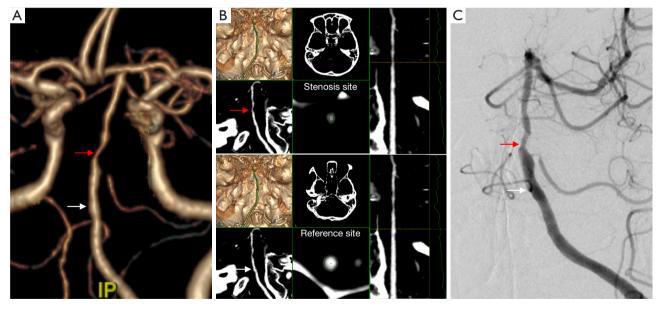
An example of measurement in basilar artery stenosis. An adult patient with a symptomatic BA stenosis. The stenosis (red arrow) and reference (white arrow) sites were decided on CTA (A). The degree of stenosis was calculated as (1 – the minimal diameter at the stenosis site/the mean diameter at the reference site) × 100%, and the degree of stenosis was 56.5% on semi-automatic method (B) (red arrow indicates stenosis site; white arrow indicates reference site). The degree of stenosis was 55.1% on DSA (C) (red arrow indicates stenosis site; white arrow indicates reference site). IP, inferior posterior; BA, basilar artery; CTA, computed tomography angiography; DSA, digital subtraction angiography.
